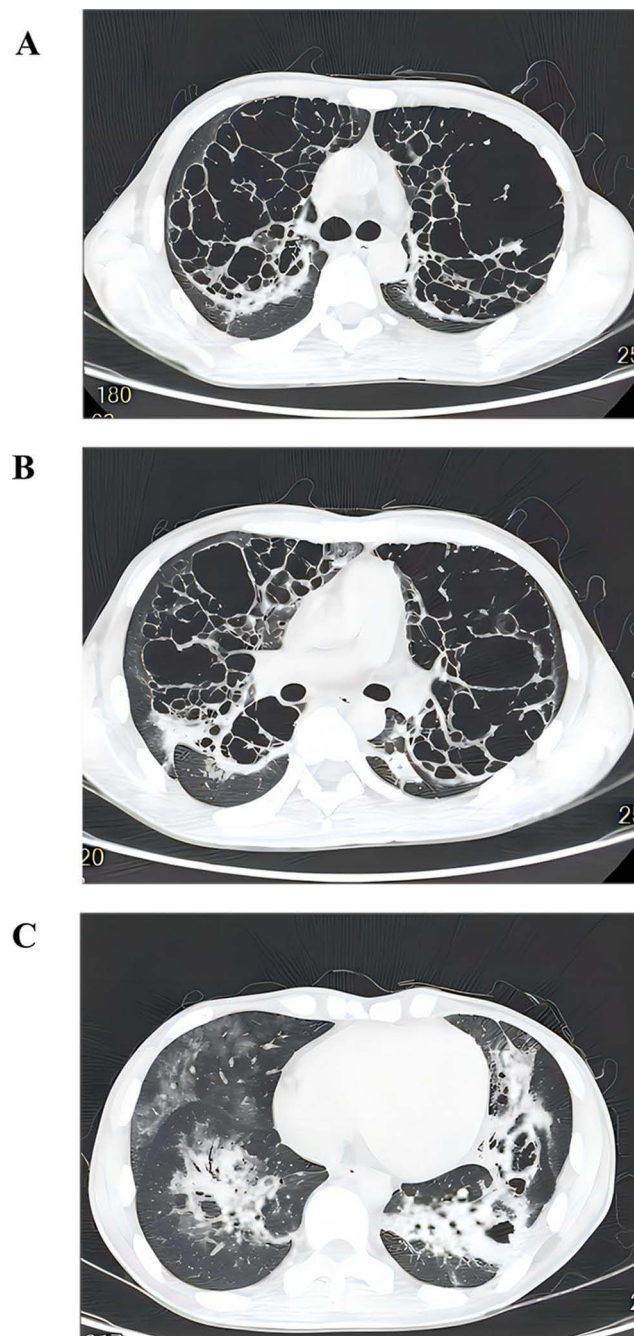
A follow-up chest HRCT scan from August 16, 2022, during the patient's hospitalization, reveals increased and enlarged lucencies in the upper lobes of both the lungs and more extensive lesions in the lower lobes compared to the images from July 26, 2022. (A) Tracheal bifurcation level: It remained predominant honeycomb with significantly less shaded infiltrated patches, the lobular interval was thinner, (B) The bronchial level of the right middle segment: Like the changes in upper lung, the honeycomb range was expanded, the lobular septum became thinner, and the nodule infiltration was significantly reduced, (C) The bronchial level of the basal segment: The scope of nodular invasion expanded and honeycomb was added.
